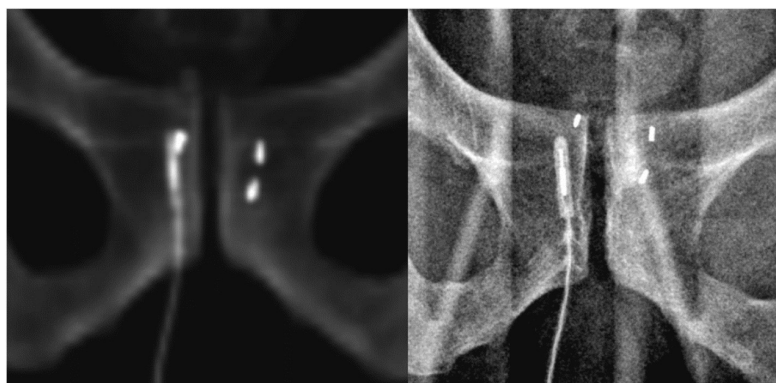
On left: reference DRR-image of transmitter and gold seeds, reconstructed from planning CT. On right: corresponding kV-image at 28th treatment fraction. 5 mm caudal migration of the transmitter can be seen between the images. Difference on distance between the gold seeds and pubic bones reveals notable prostate interfraction motion.
